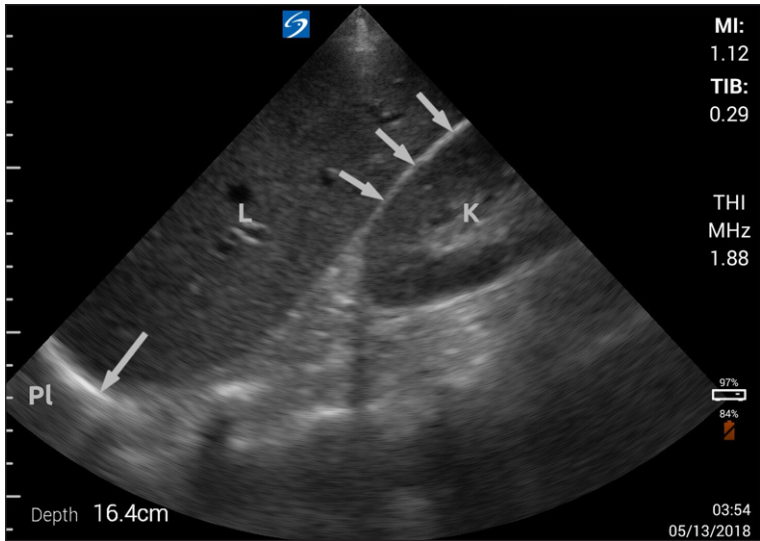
An ultrasound image of the right upper abdominal quadrant
